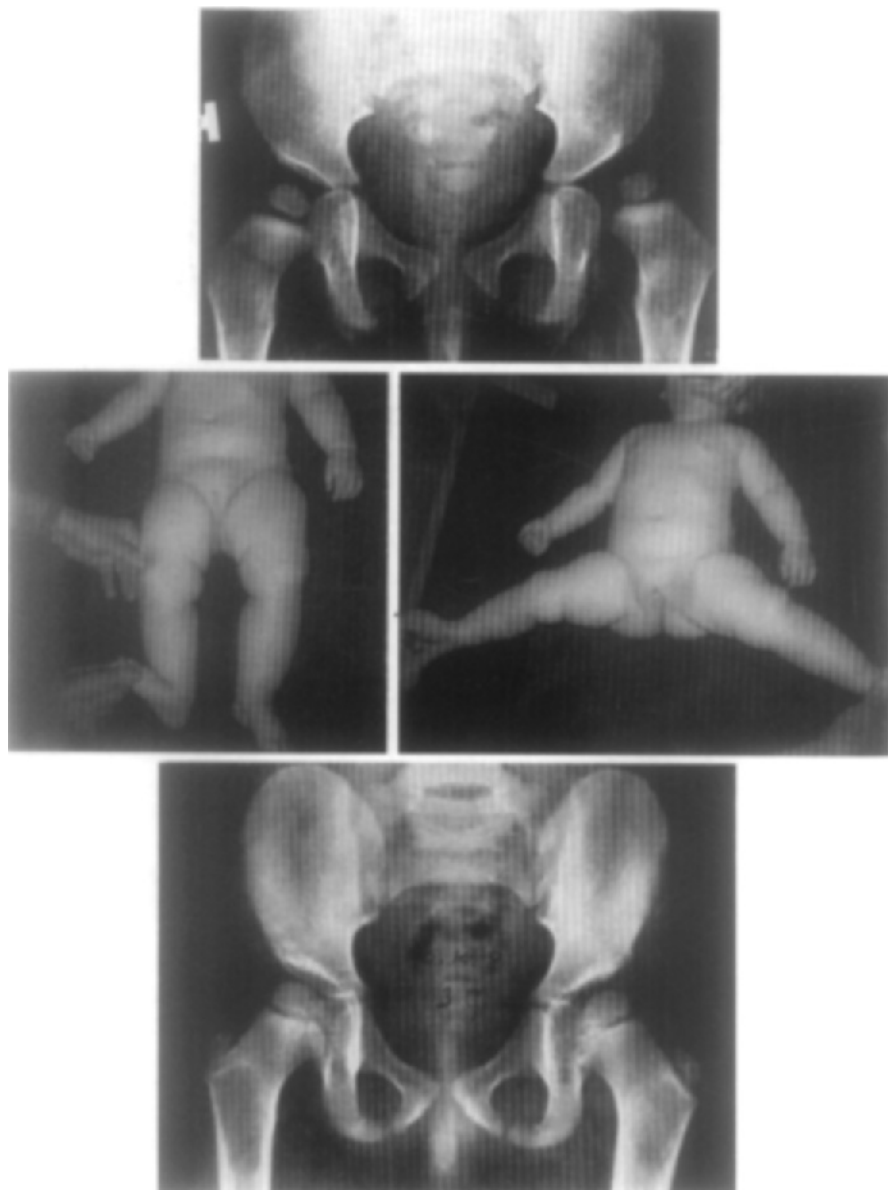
Another clumsy baby-girl with hypermobile joints and bilateral instability in the hips at birth. With our routine treatment both joints became stable in the reduced position within three months. At a routine follow-up at the age of 12 months the left hip was unstable again and X-rays revealed dysplasia of the acetabular roof. After 4 months of renewed treatment in our frame the hip became stable and the acetabular roof developed satisfactorily. The general configuration of the girl is now quite normal.
